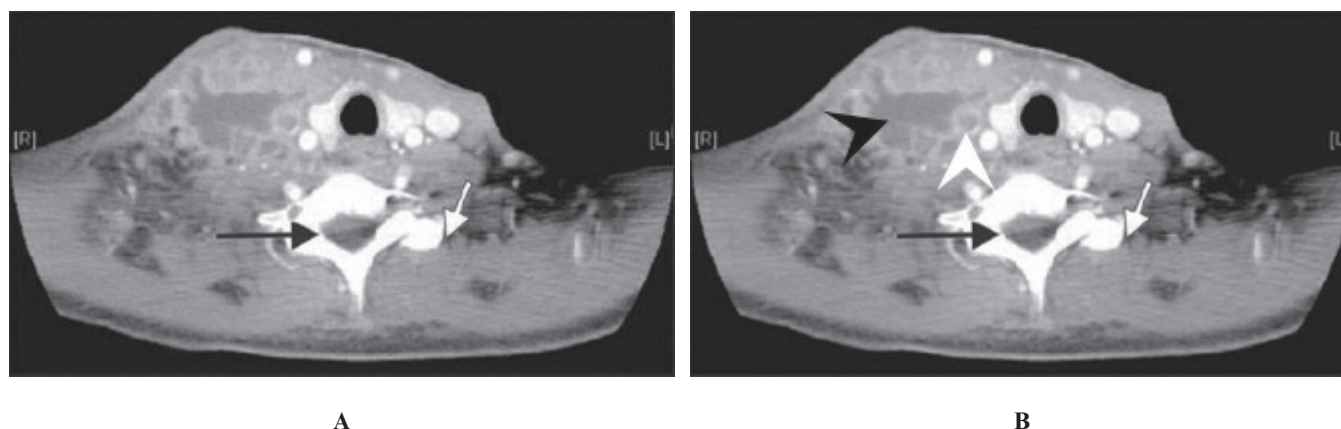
A, Contrast-enhanced axial computed tomographic image of the neck as originally published. The original caption read, "The black arrow indicates the multiloculated abscess. The white arrow indicates the right internal jugular vein with a tiny ring of contrast around the occluding thrombus." A translation of the arrows has occurred, shifting them markedly posterior and to the left from their intended structures. Reproduced with permission from Barnett and Medzon.² B, If the translation were reversed, the arrows would be accurate. A white arrowhead points to the actual location of the right internal jugular vein and a black arrowhead to a multiloculated abscess. The reviewing emergency physicians indicated that this labeling error could have affected both clinical management and educational value. This image is summarized in Table 3, error 2.
